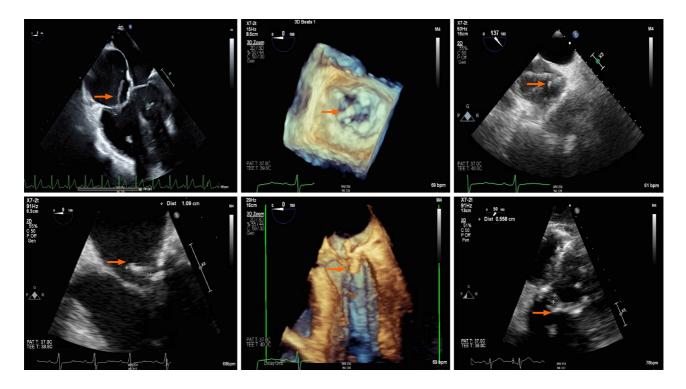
Echocardiographic images of vegetations.
